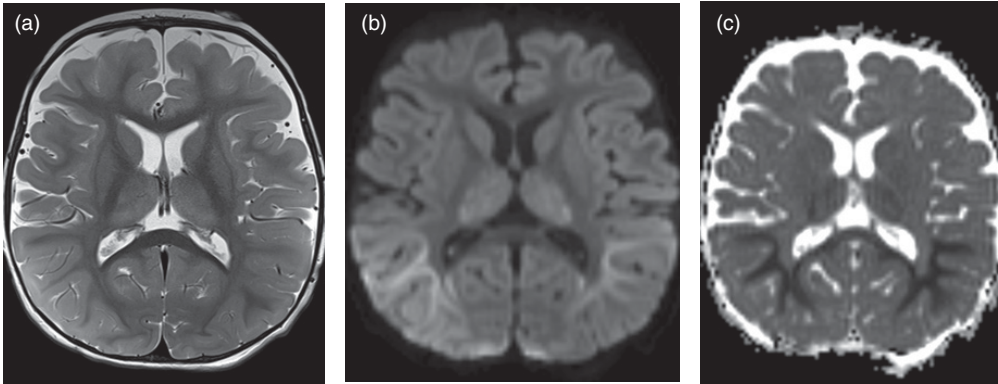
A 1-year-old male with POLG-associated Alpers syndrome, manifest as refractory status epilepticus, myoclonus, and liver failure. (a) Axial T2-weighted imaging demonstrates thalamic T2 hyperintensity and posterior quadrant cortical/subcortical T2 prolongation, much more conspicuous on (b) an axial diffusion trace and (c) apparent diffusion coefficient (ADC) maps.
